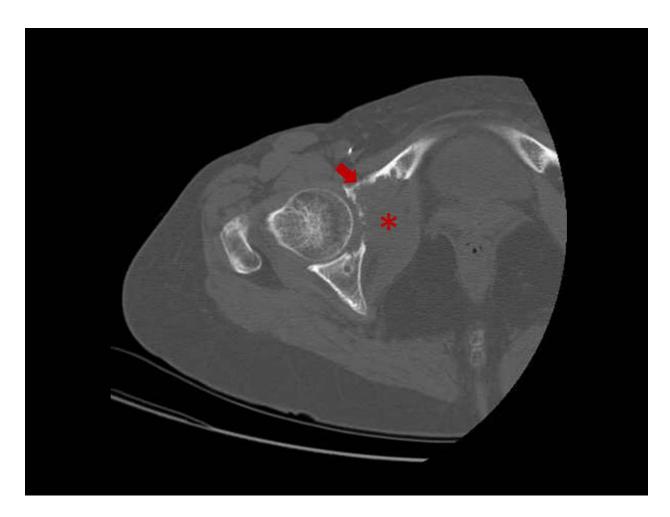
Dedifferentiated chondrosarcoma. CT reveals a osteolytic lesion in the superior ramus of the right pubis with chondroid mineralization (arrow), which is a feature of a well-differentiated chondrogenic tumor. The cortex penetration and a soft tissue component (*) suggests an aggressive pattern.
